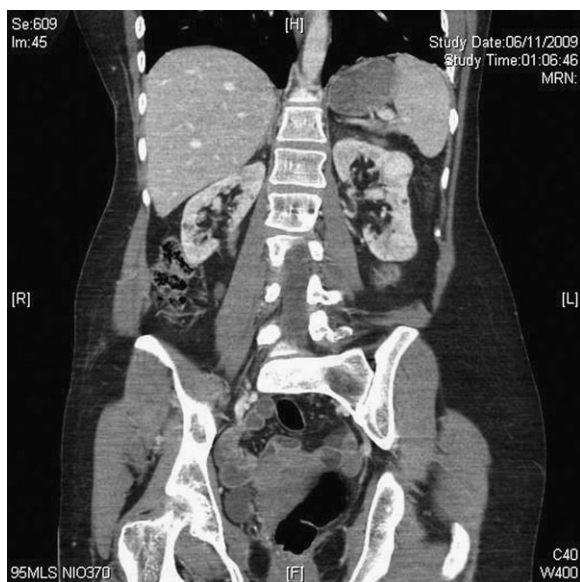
Coronal CT with intravenous contrast.
